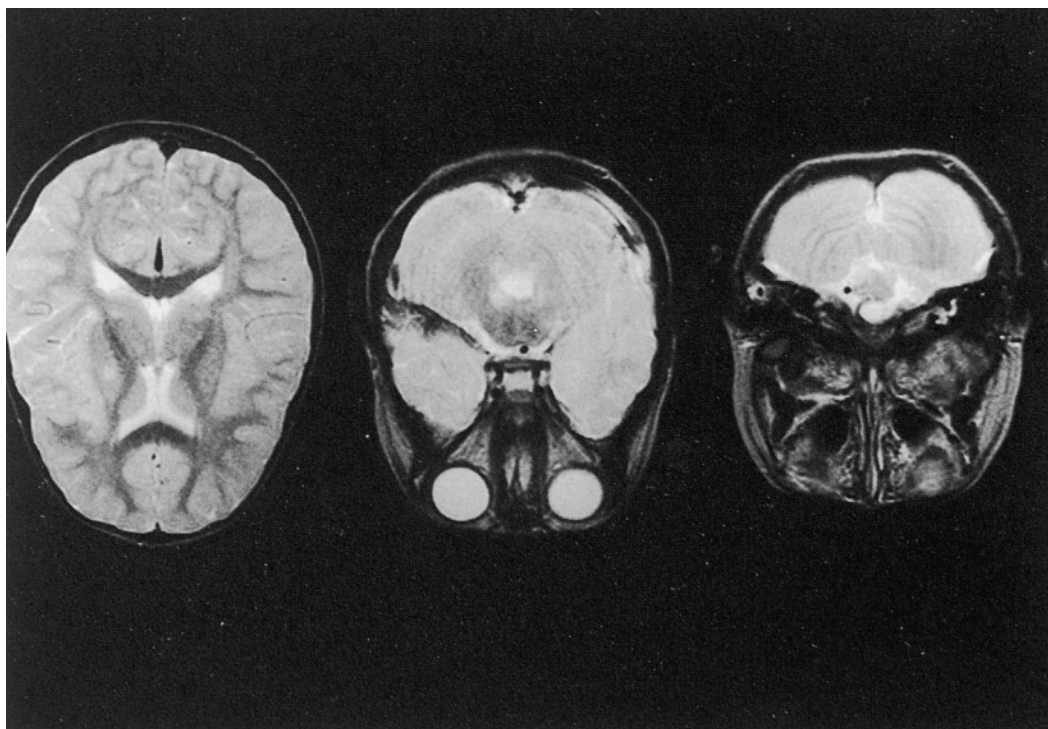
Brain MRI T2-weighted scan performed on the second day after admission shows areas of high signal intensity disseminated in superior portion of medulla oblongata, dorsal portion of pons, basal nuclei and thalamus.
